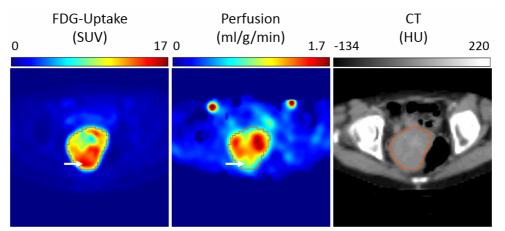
Transversal slices of consecutive FDG PET/CT (left/right) and [¹⁵O]water PET (middle) in a patient with advanced cervical carcinoma prior to therapy. There is significant flowmetabolism mismatch predominantly in the dorsal part of the tumor (arrows). From (1).
